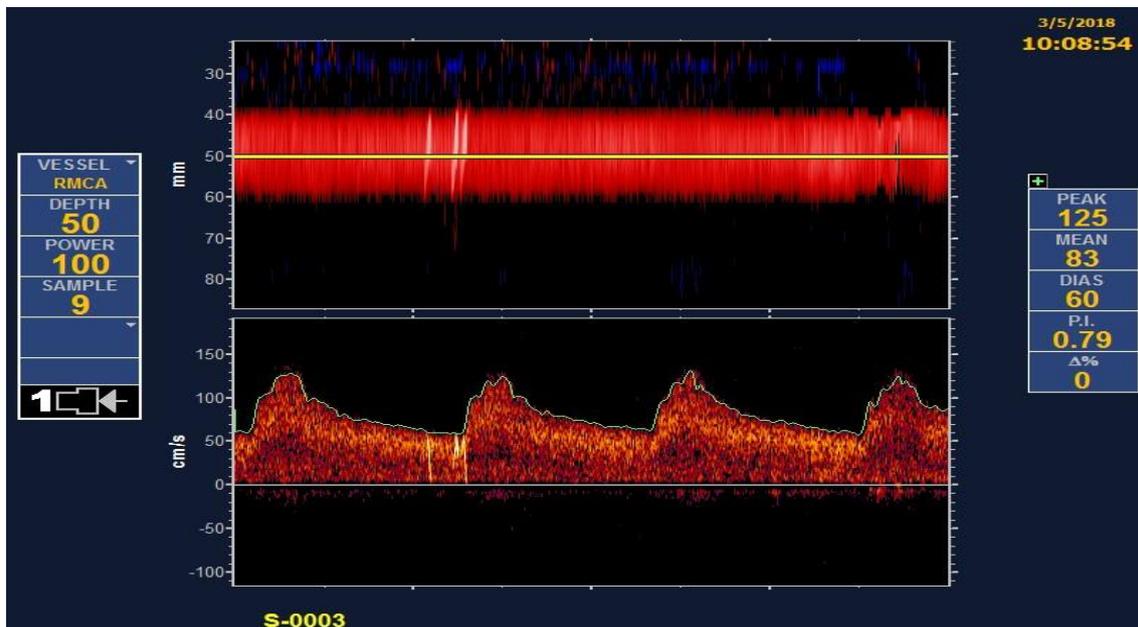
TCD showing normal baseline flow in the right MCA with high-intensity signals related to microemboli. DIAS: end-diastolic velocity, MEAN: mean flow velocity, PEAK: peak systolic velocity, P.I.: pulsatility index, RMCA: right middle cerebral artery, TCD: transcranial Doppler. Courtesy of Dr. Zsolt Garami.
